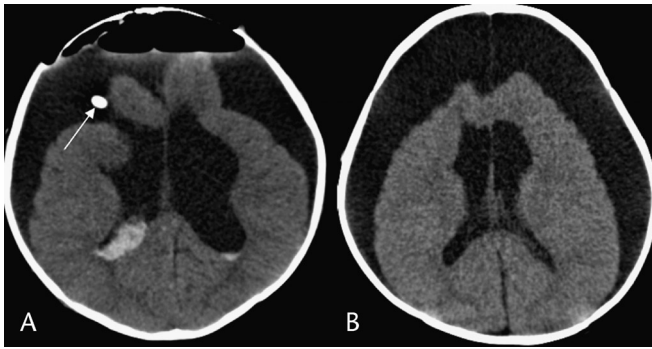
Choroid plexus papilloma postresection. A, Immediate postoperative noncontrast CT shows bifrontal craniotomy, large extracerebral air and fluid collections, a small amount of intraventricular hemorrhage, and moderately large lateral ventricles. A right frontal catheter (white arrow) is in place at the site of continuity between the extracerebral space and ventricular system. Noncontrast CT (B) 1 month after surgery shows smaller ventricles but larger extracerebral collections. The ventricular catheter was then replaced with an extracerebral (subdural) catheter.
